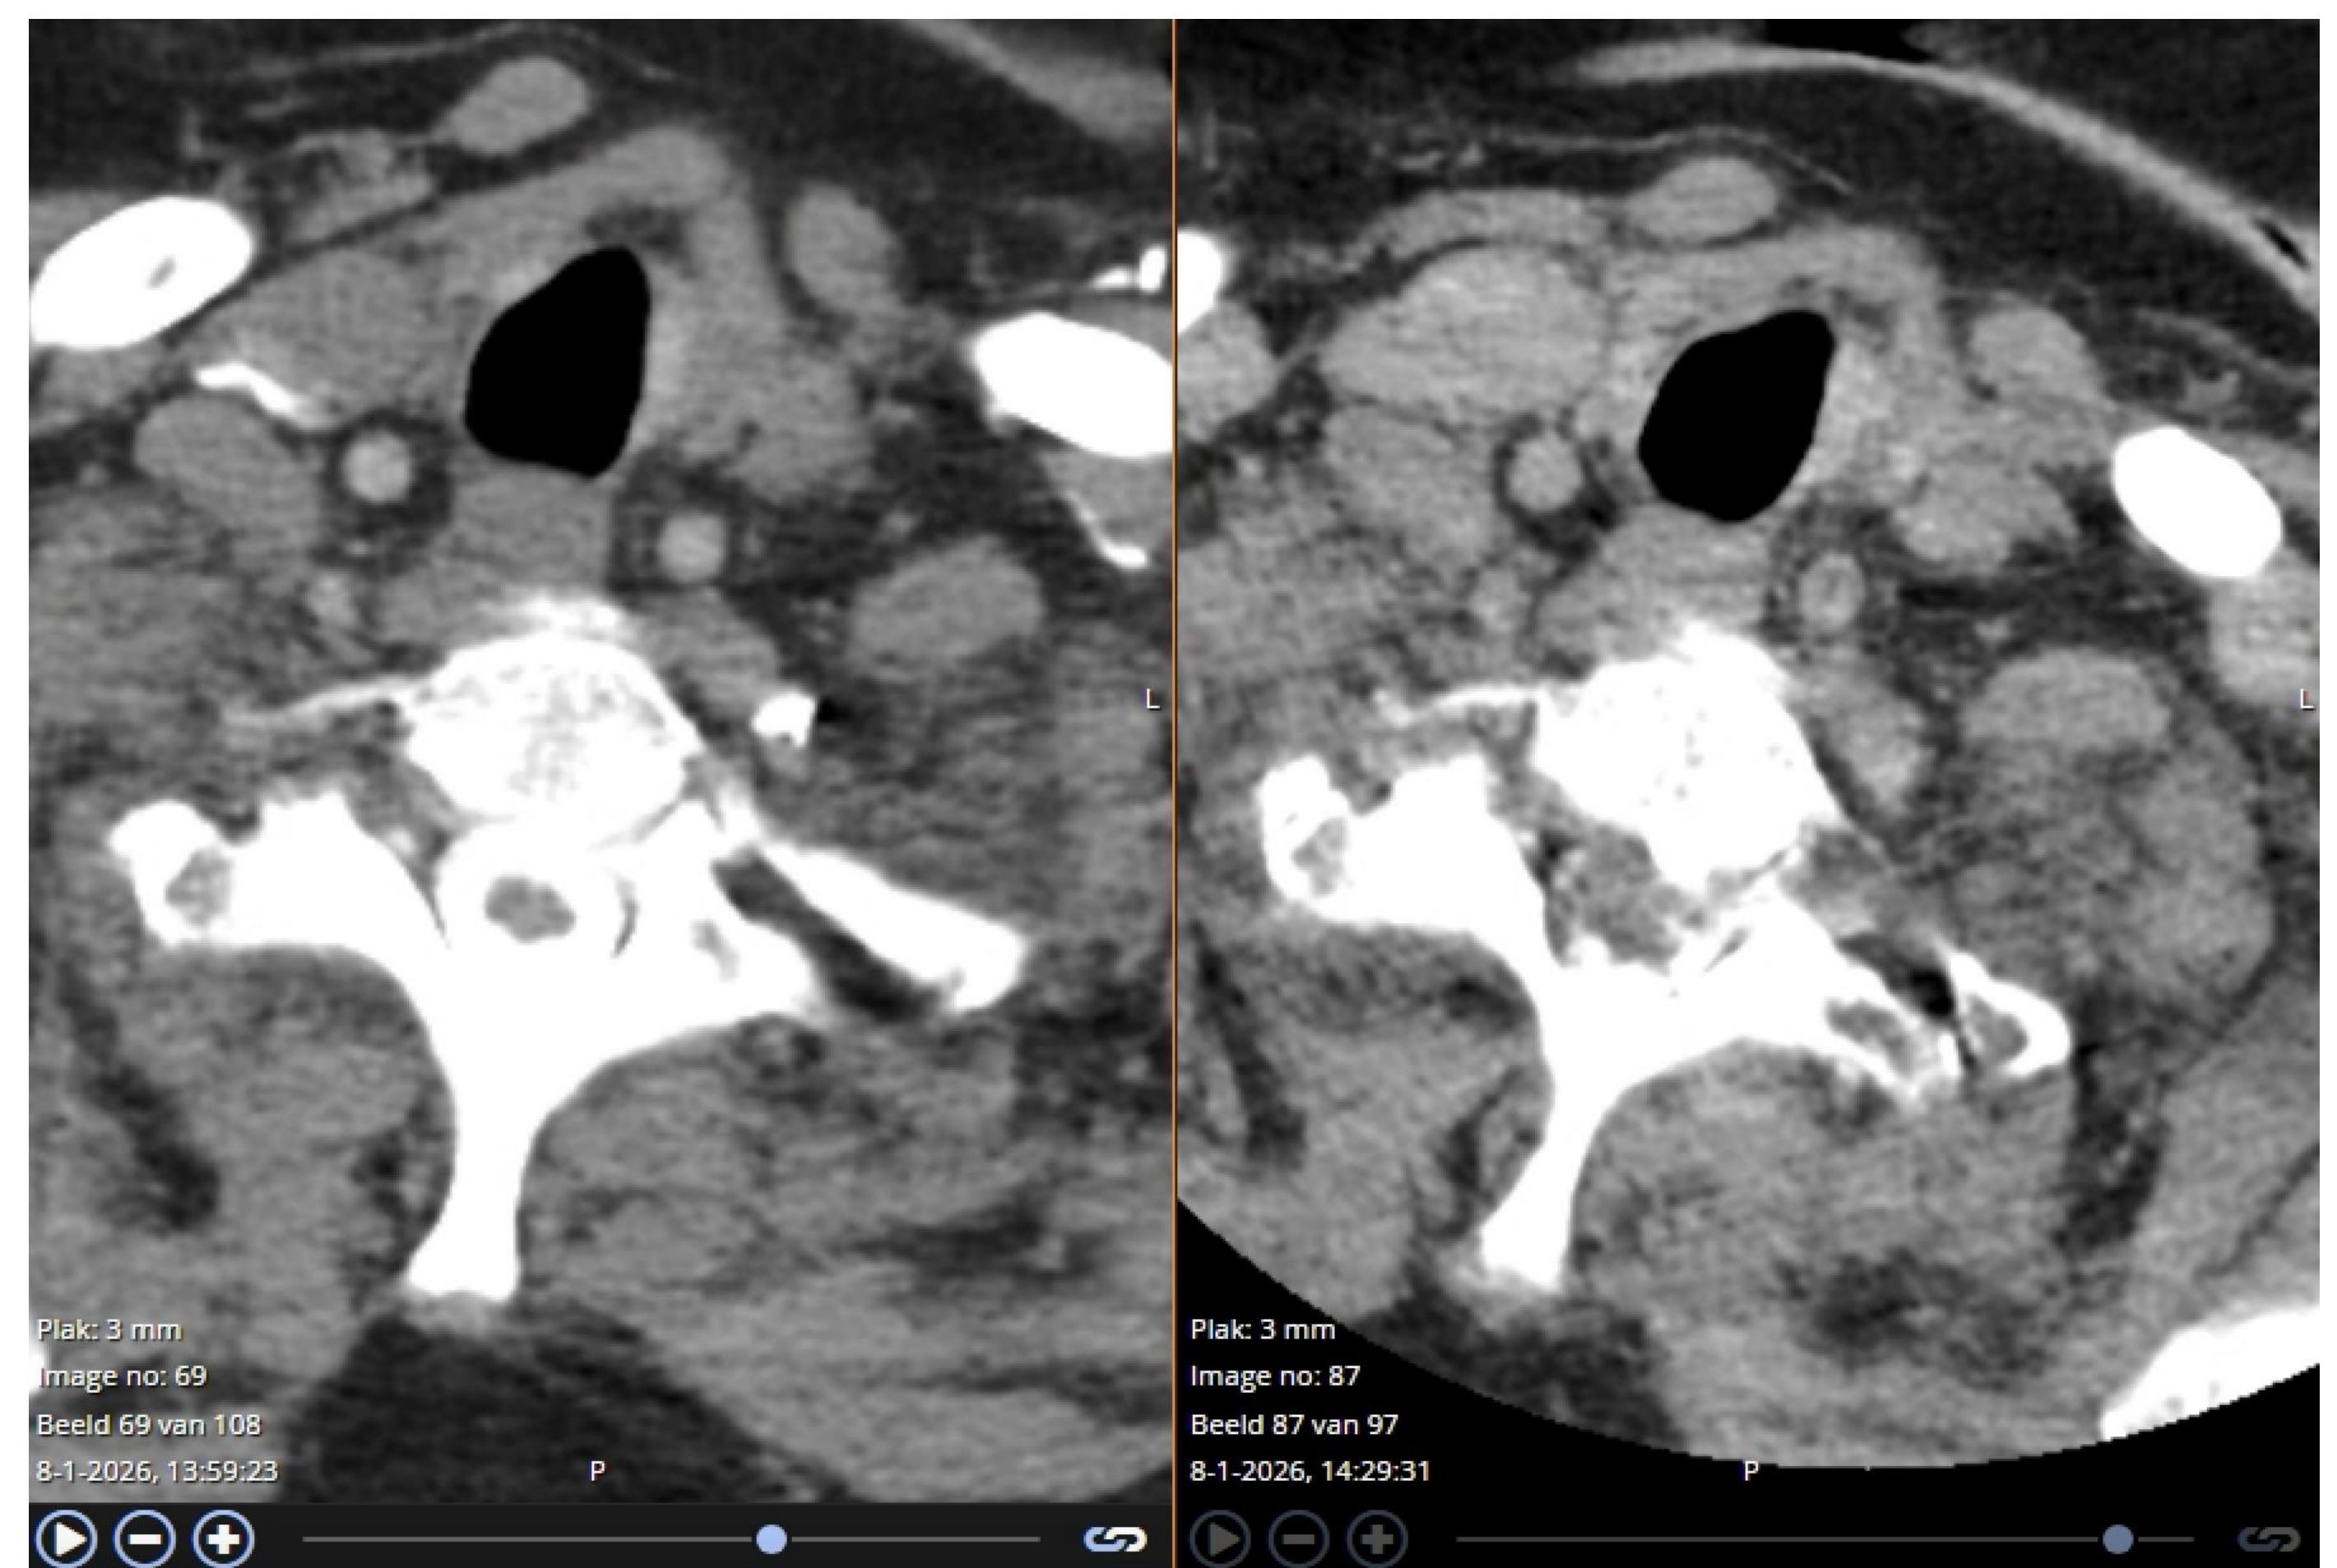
Pre- (left) and post-procedure (right) CT, showing an adequate distribution of the sealing material.
